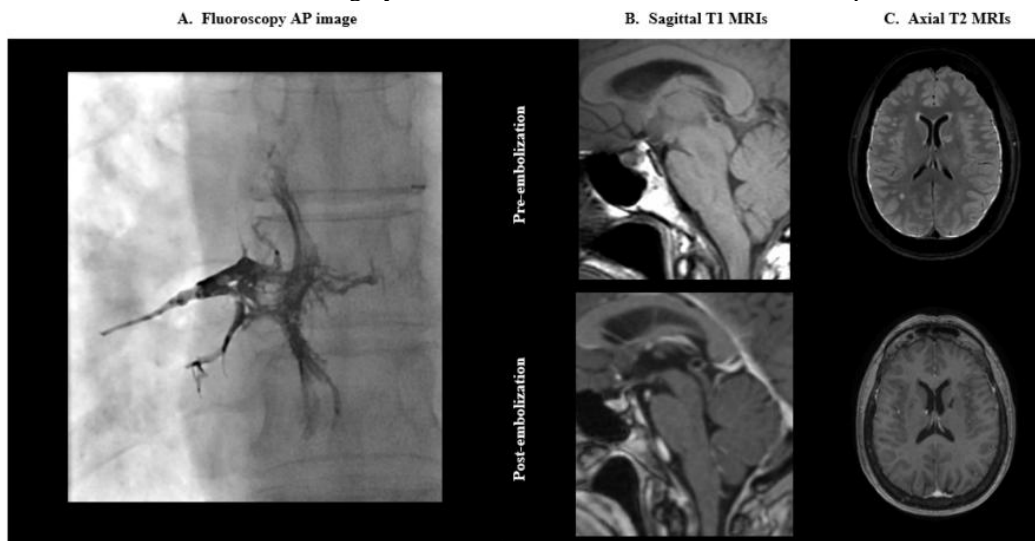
Embolization cast of paraspinal veins and the adjacent epidural venous plexus at the level of right T7. B and C. Pre- and 3-month post-embolization sagittal T1 axial T2 MRIs of the patient. Pre-embolization MRI shows characteristic imaging findings of intracranial hypotension including diffuse pachymeningeal enhancement, pontine belly flattening and narrowing of the mamillary pontine distance. Post-embolization MRI shows marked improvement of the previous findings, including resolution of diffuse pachymeningeal thickening, increase in the size of ventricles, increase in the suprasellar cistern and prepontine cistern volumes, as well as improved pontomedullary distance and midbrain pontine angle.
